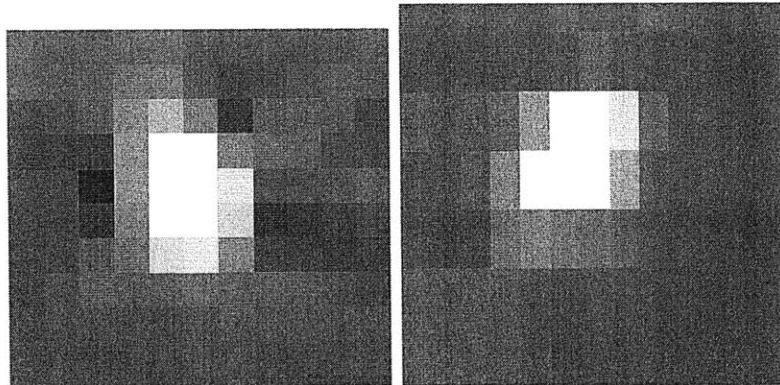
An axial (left) and sagittal (right) closeup view of a CT seed. The sagittal view has been stretched in the vertical axis according to the slice:pixel ratio to form an isometric view. Each pixel width (and half the vertical pixel height in the sagittal view) corresponds to 0.625 mm.
